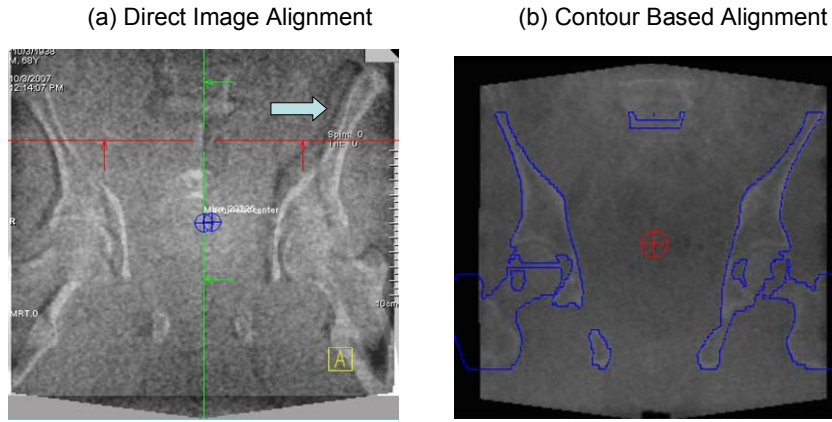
(a) The planning CT (bone appeared in white) is superimposed in the MV-CBCT (bone appeared in bark). The arrow pointed the mis-alignment in the region. (b) The contour of the pelvic bone (in blue lines) is superimposed in the MV-CBCT (bone appears in gray).
